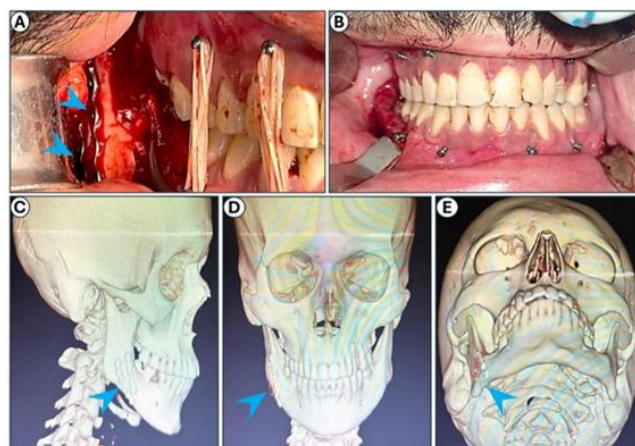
Surgical approach and postoperative imaging. (A) Osteosynthesis of the mandibular angle fracture using two 2.0 mm plates. (B) Stable occlusion after fixation. (C–E) Postoperative three-dimensional computed tomography (CT) reconstruction showing the fixation hardware in position. The blue arrow indicates the osteosynthesis material (Source: Author).
